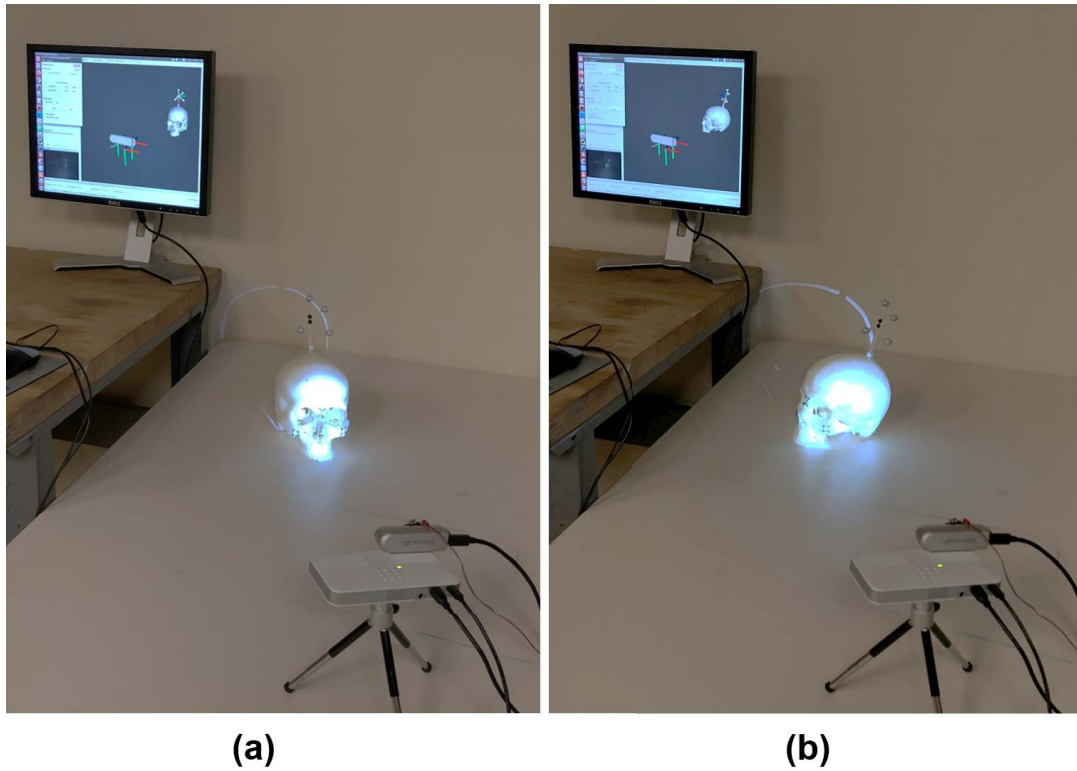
Overlaying the CT skull model on patient The registered CT skull model was overlaid on the physical skull via projection mapping. Surgeon can roughly determine the registration accuracy based on the model alignment.
